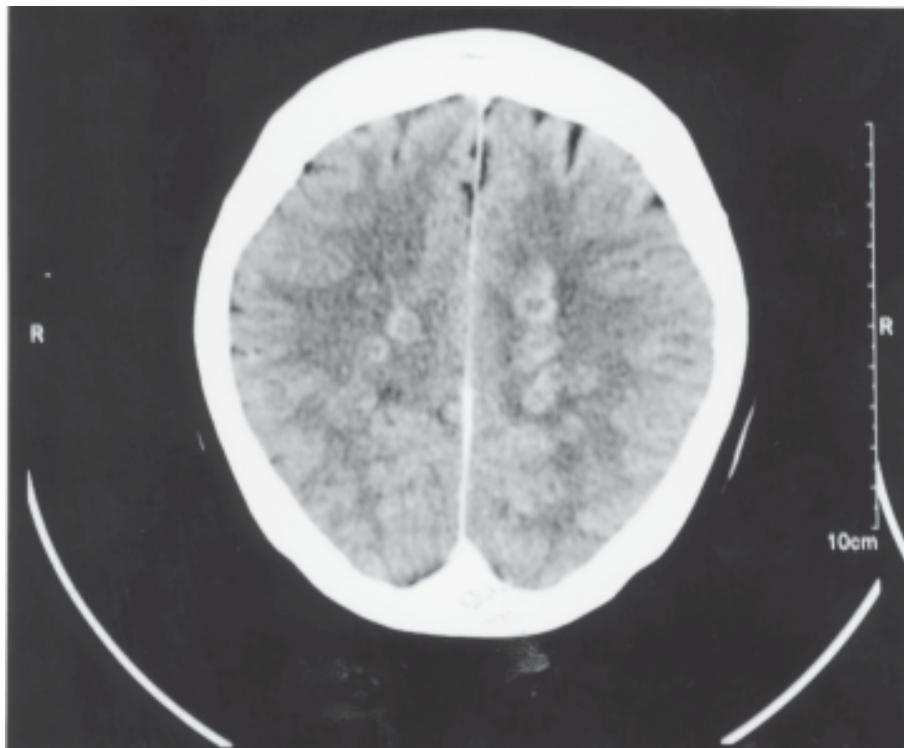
Axial section of contrast-enhanced CT brain scan showing multiple well circumscribed ring enhancing rounded lesions with central mural nodule and minimal surrounding oedema.
